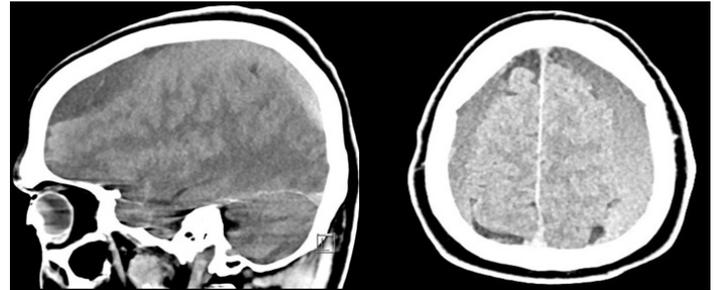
Brain CT after the patient had acute worsening mental status change showing bilateral subdural hematomas with mass effect, uncus herniation.
